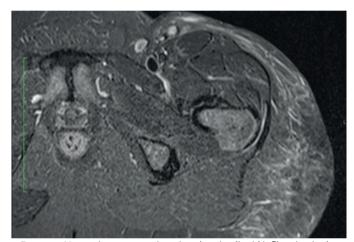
Magnetic resonance imaging showing liquid infiltration in the subcutaneous of the gluteal region
